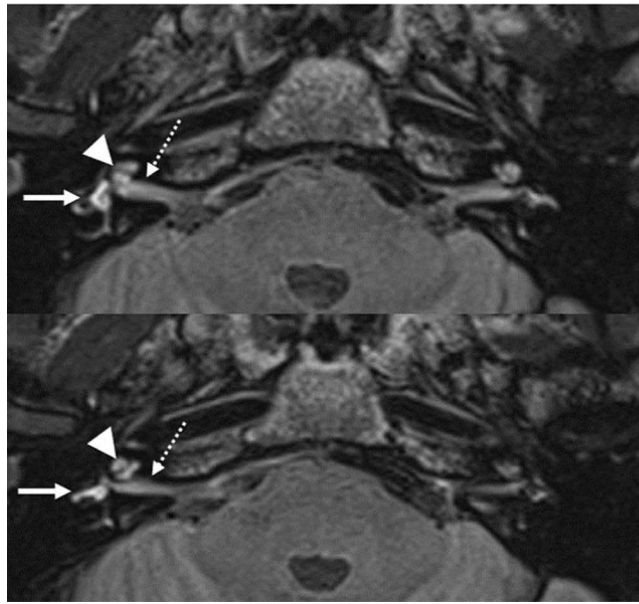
Delayed post-contrast enhanced 3D-FLAIR images of patients with acute unilateral vestibulopathy. Delayed post-contrast enhanced 3D-FLAIR MRI revealed abnormally increased signal intensity in the right vestibular nerve and right vestibule compared to the contralateral side. Dashed arrows: vestibular nerve; short arrows: cochlea; solid arrows: vestibule.
